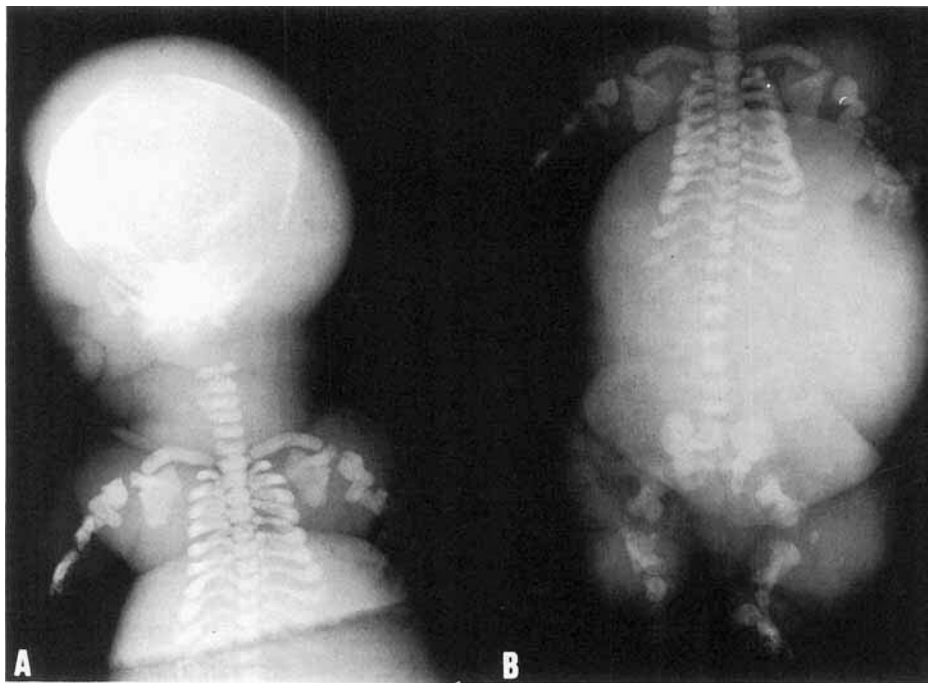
Post-mortem radiographs of probanda. A: Head, neck, and upper thorax: generalized hydrops; artefactual separation of skeleton of head and cervical spine. Small facial skeleton, narrow skull base; increased bone density; bowtie-shaped vertebrae; plump but rather long clavicles with boomerang shape; completely ossified scapulae; extreme shortness of hyperdense ribs. B: Trunk and limbs: horizontal orientation of short ribs with spatulated ends; hypoplastic hyperdense pelvic bones; dumbbell-shaped long bones in limbs, with extreme metaphyseal widening and diaphyseal constriction; seven carpal and all tarsal bones ossified, but no secondary epiphyseal centers of ossification visualized in long bones.
